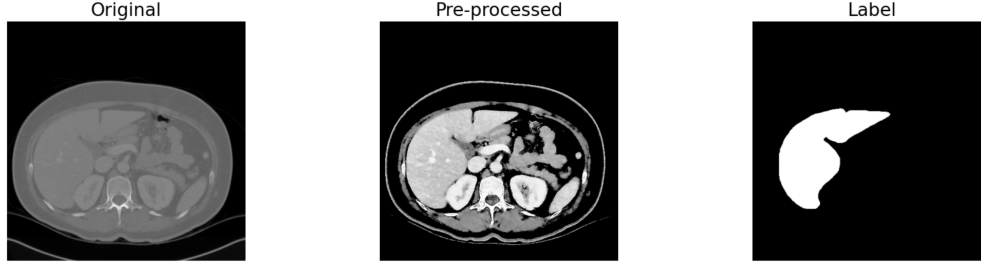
Pre-processing result of CT images.
